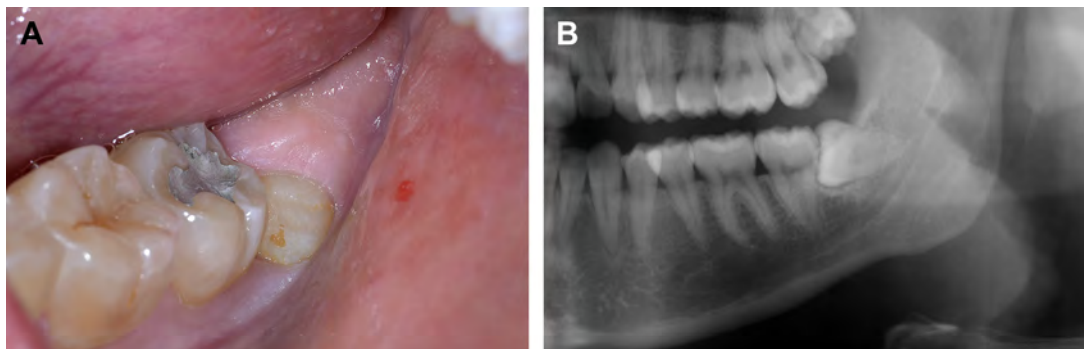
(A) Partial bone impacted mandibular third molar. (B) Radiograph of partial bone impacted mandibular third molar.
